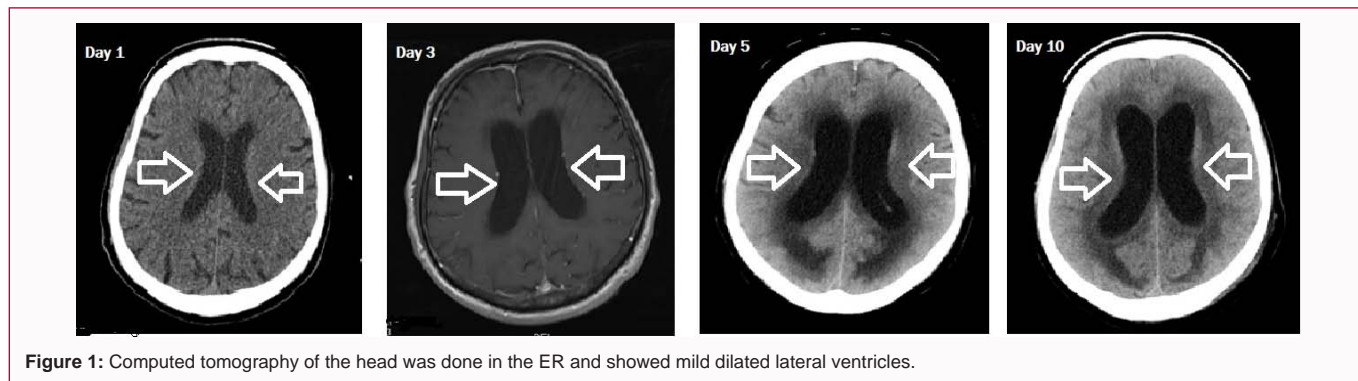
Computed tomography of the head was done in the ER and showed mild dilated lateral ventricles.
